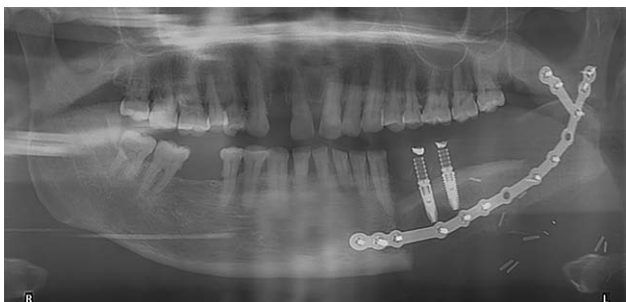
Postoperative panoramic x-ray of the reconstructed mandible.
